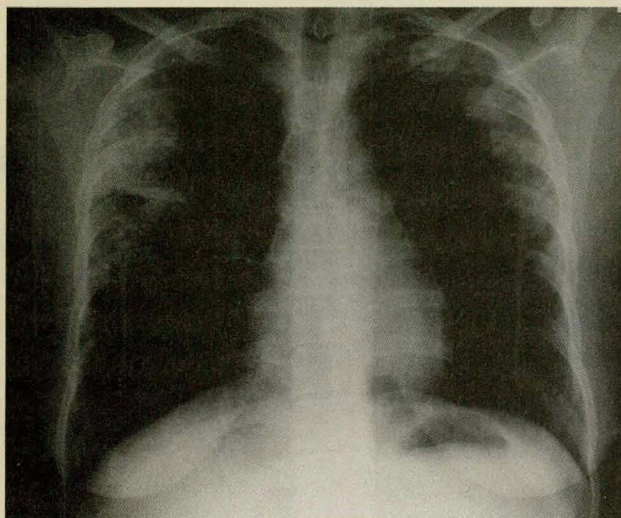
Posteroanterior chest roentgenogram revealing bilateral peripheral infiltrates (with upper lobe predominance) in the absence of hilar or mediastinal adenopathy.
